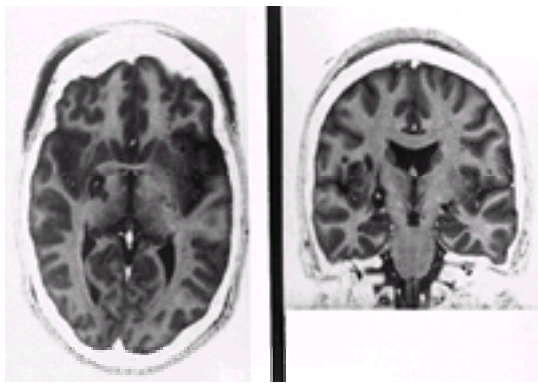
Axial and coronal MRI of the brain, obtained 4 h after pallidotomy. Fast spin echo inversion recovery sequence; TI, 200 ms; TR, 3000 ms; TE, 40 ms; slice thickness, 2 mm; interslice spacing, 0. (A) Axial image at the level of the AC–PC line; (B) coronal image at the middle of the lesion–edema complex (dark outer ring and central white area). Note the edema crossing over to the thalamus representing the destruction of this pathway.
